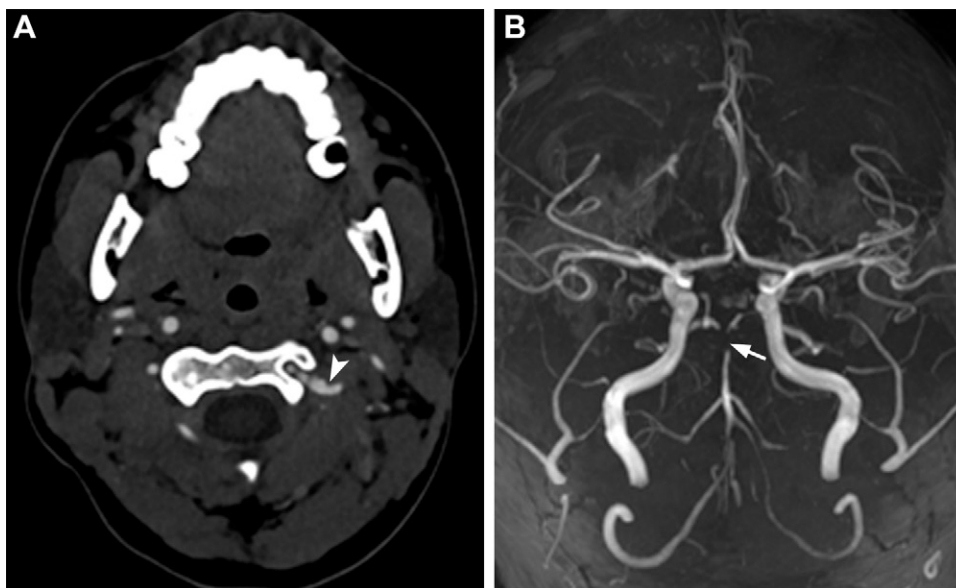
Vertebral artery dissection in a 16-year-old adolescent boy who presented with headache, dizzy spells, and vertigo. (A) Axial CT angiographic image of the neck shows focal irregularity and subtle narrowing of the left V3 vertebral artery segment (arrowhead). (B) Three-dimensional maximum intensity projection MR angiographic image of the circle of Willis shows a diminutive caliber of the left intracranial vertebral artery and basilar tip occlusion (arrow).
